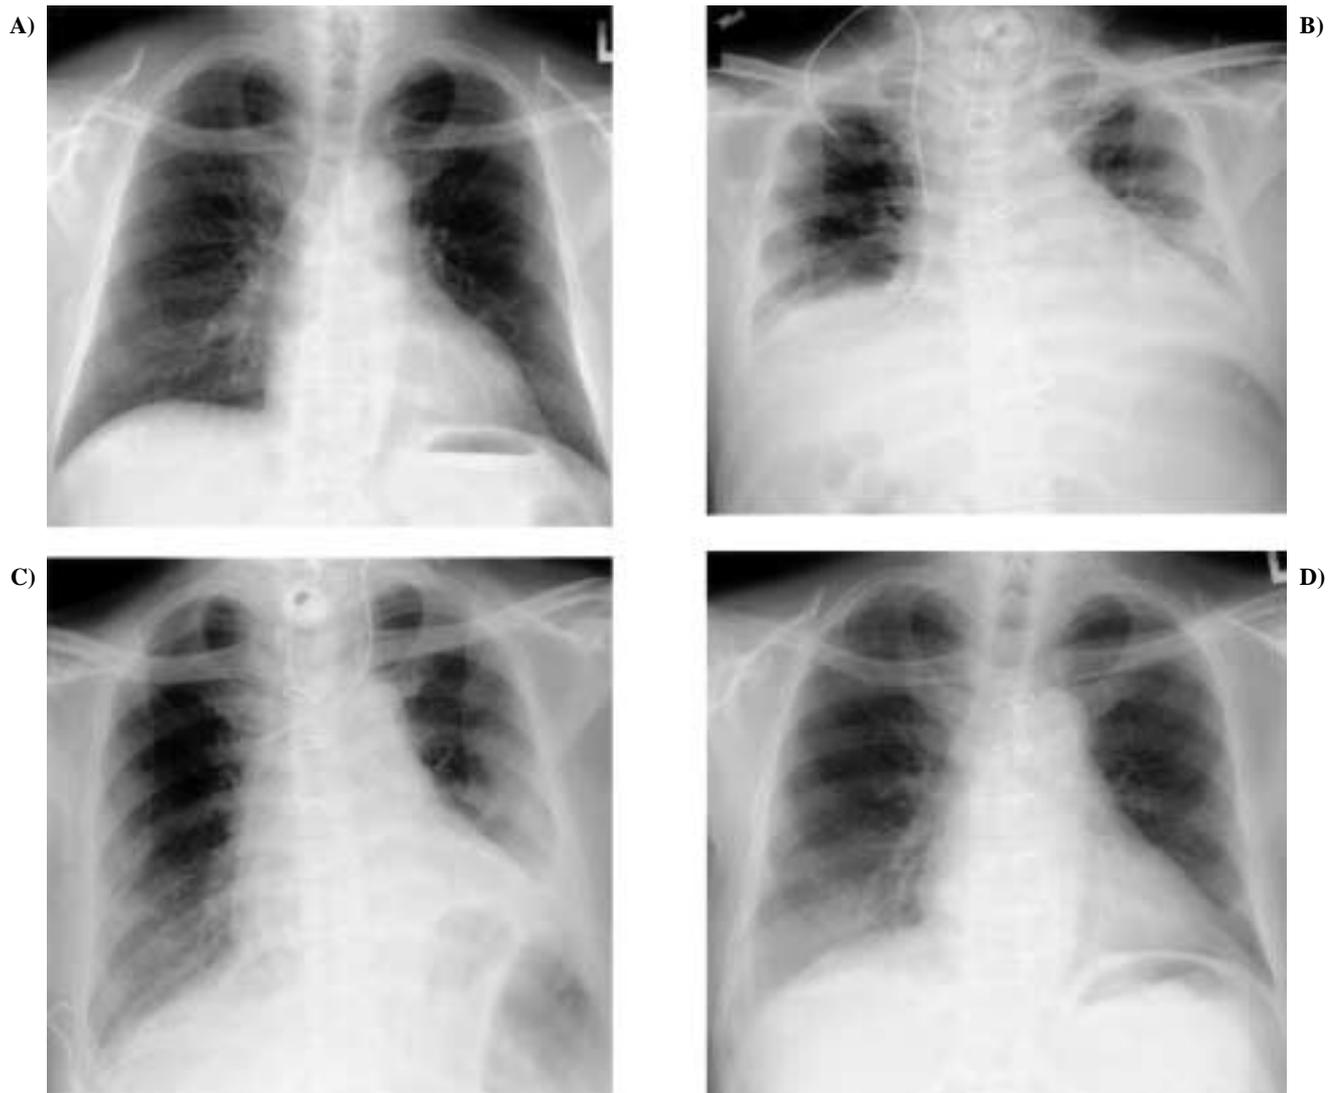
Change in the chest x-ray image of case 1. A) pre-cardiac surgery, B) 24 days after cardiac surgery, C) just after diaphragmatic plication (53 days after cardiac surgery), D) one year after surgery.
